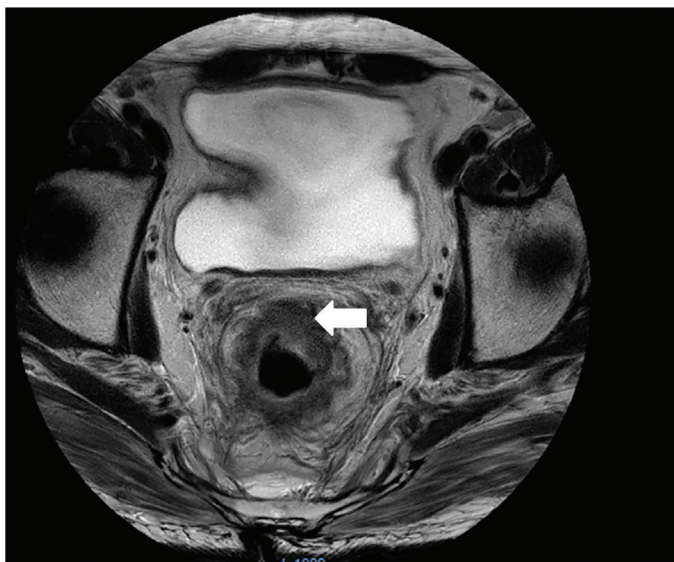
Axial high-resolution T2-weighted MRI of a 56-year-old female patient showing a rectal tumor (arrow). The tumor-mesorectal fascia relationship is demonstrated and used as a reference for ROI placement on the solid tumor component for ADC measurements, avoiding non-solid areas
